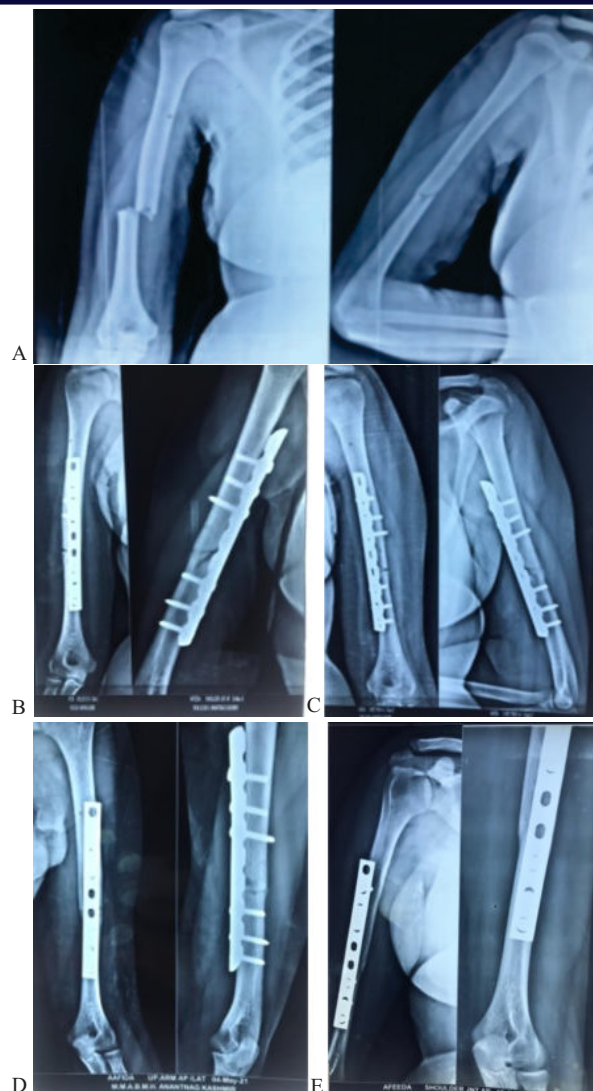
A (Radiograph showing fracture shaft of humerus), B (Immediate post-operative radiograph showing fracture fixation with LCDCP), C (Radiograph of 3 months follow-up), D (5 Month follow-up radiograph showing delayed union) and E (Radiograph at 6 weeks follow-up post bone marrow injection showing complete union)
